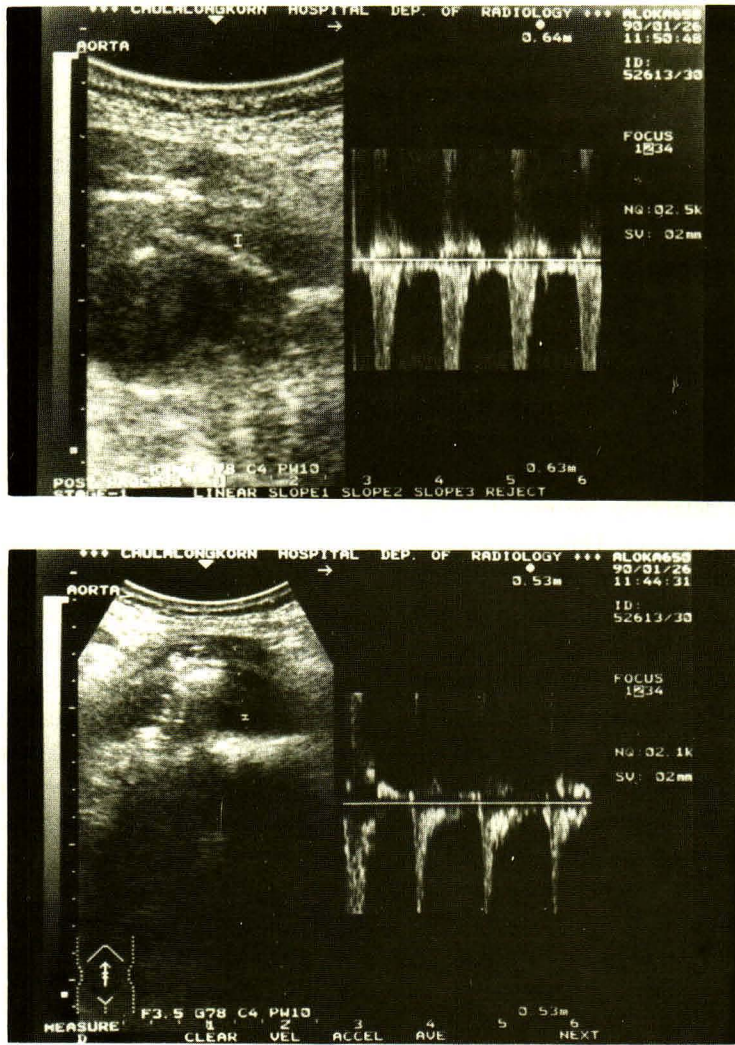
A. Doppler study of the anterior narrow lumen showing high arterial flow. B. Doppler study of the large posterior space also demonstrating high, but less, arterial flow in the same direction as (A).
